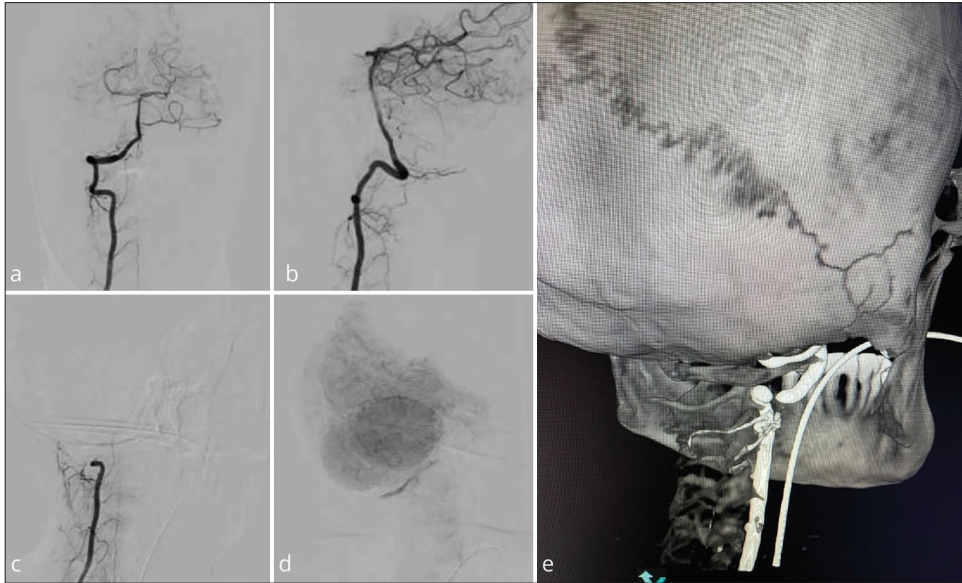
2D DSA angiogram, right vertebral artery (VA); (a and b) AP and lateral view during the arterial phase with a neutral position. (c) Right VA injection, arterial phase. (d) Capillary phase of right VA. (e) XPER computed tomography angiogram with head rotation.
